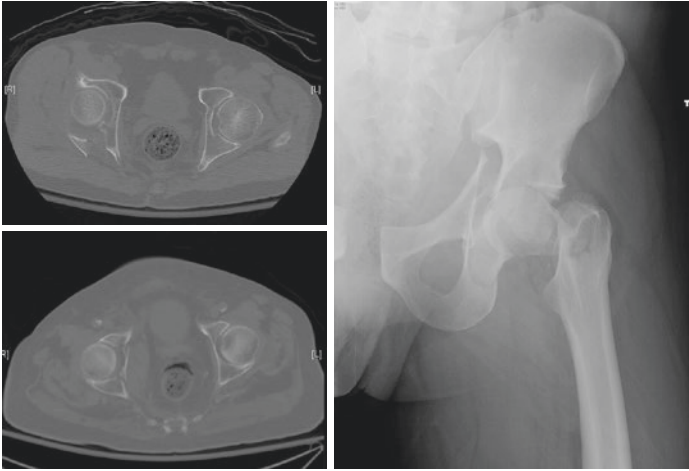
Representative CT and radiographic images of acetabular fractures
